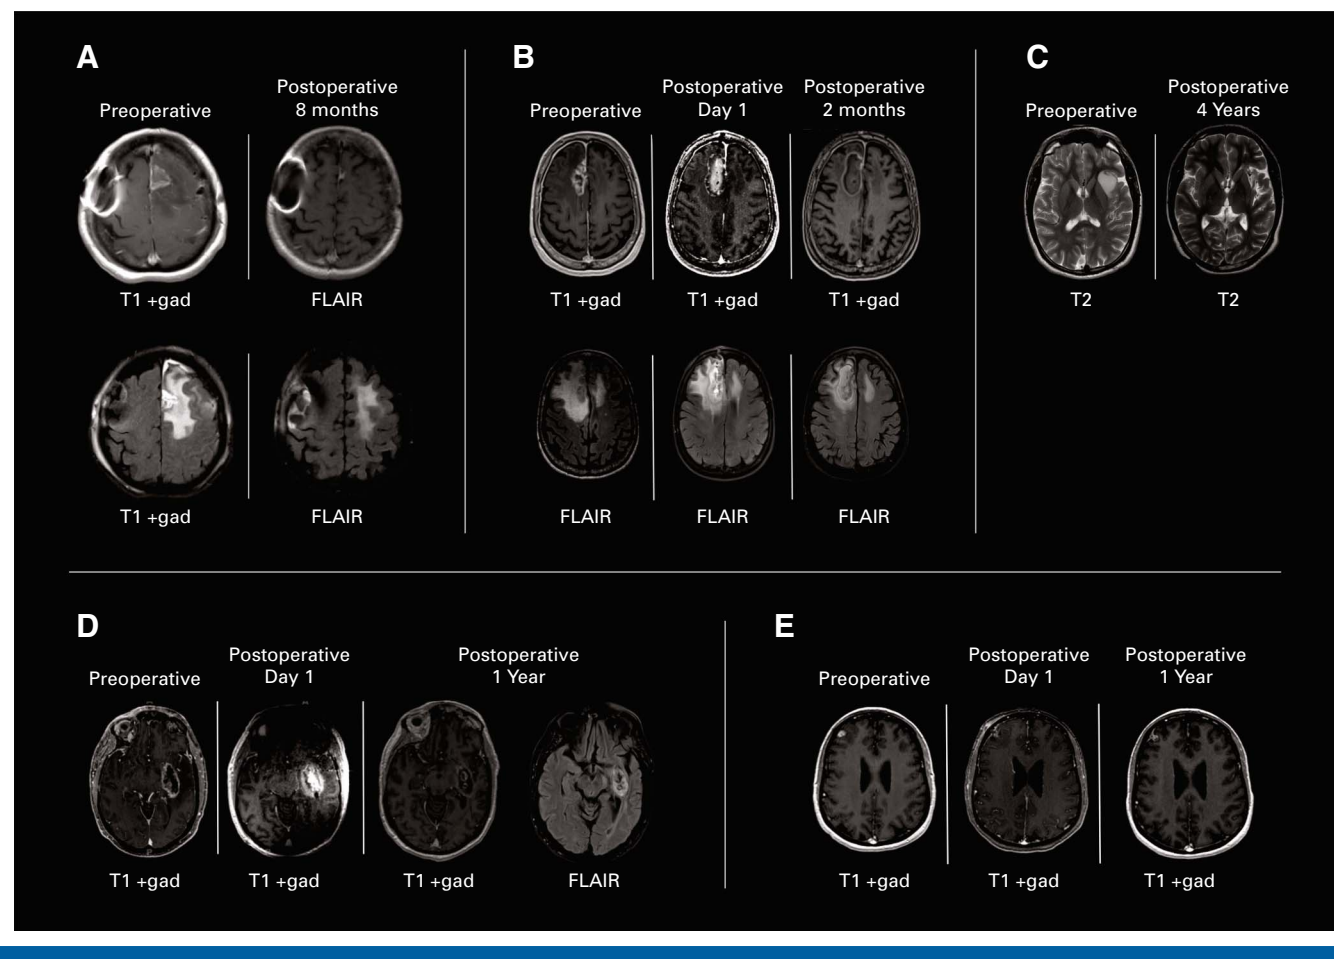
Radiographic changes over time from laser ablation cases of varying pathology. (A) Recurrent GBM; (B) glioma radiation necrosis; (C) newly diagnosed low-grade glioma; (D) newly diagnosed GBM; (E) recurrent brain metastasis.
